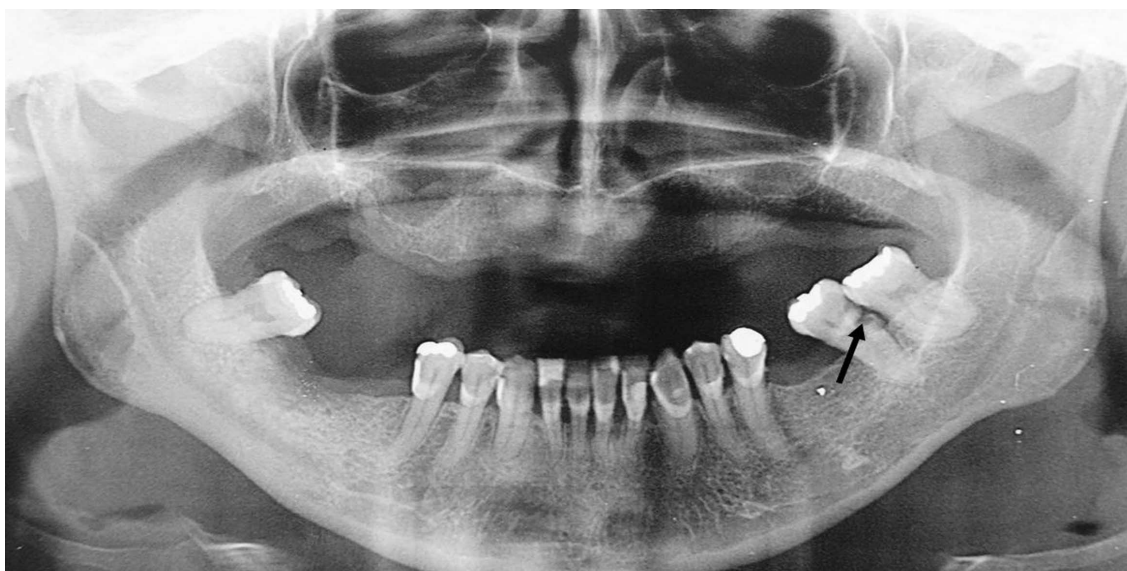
Root surface carie lesion (arrow) in a posterior tooth panoramic radiographic examination.
